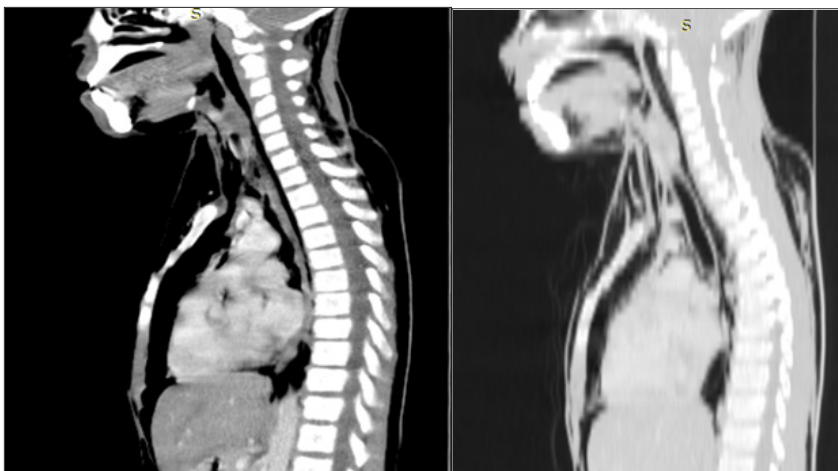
coronal sections of chest and neck CT-scan shows air in mediastinum compartment and subcutaneous tissue and grossly normal radio-anatomic image of major airodigestive structures.
